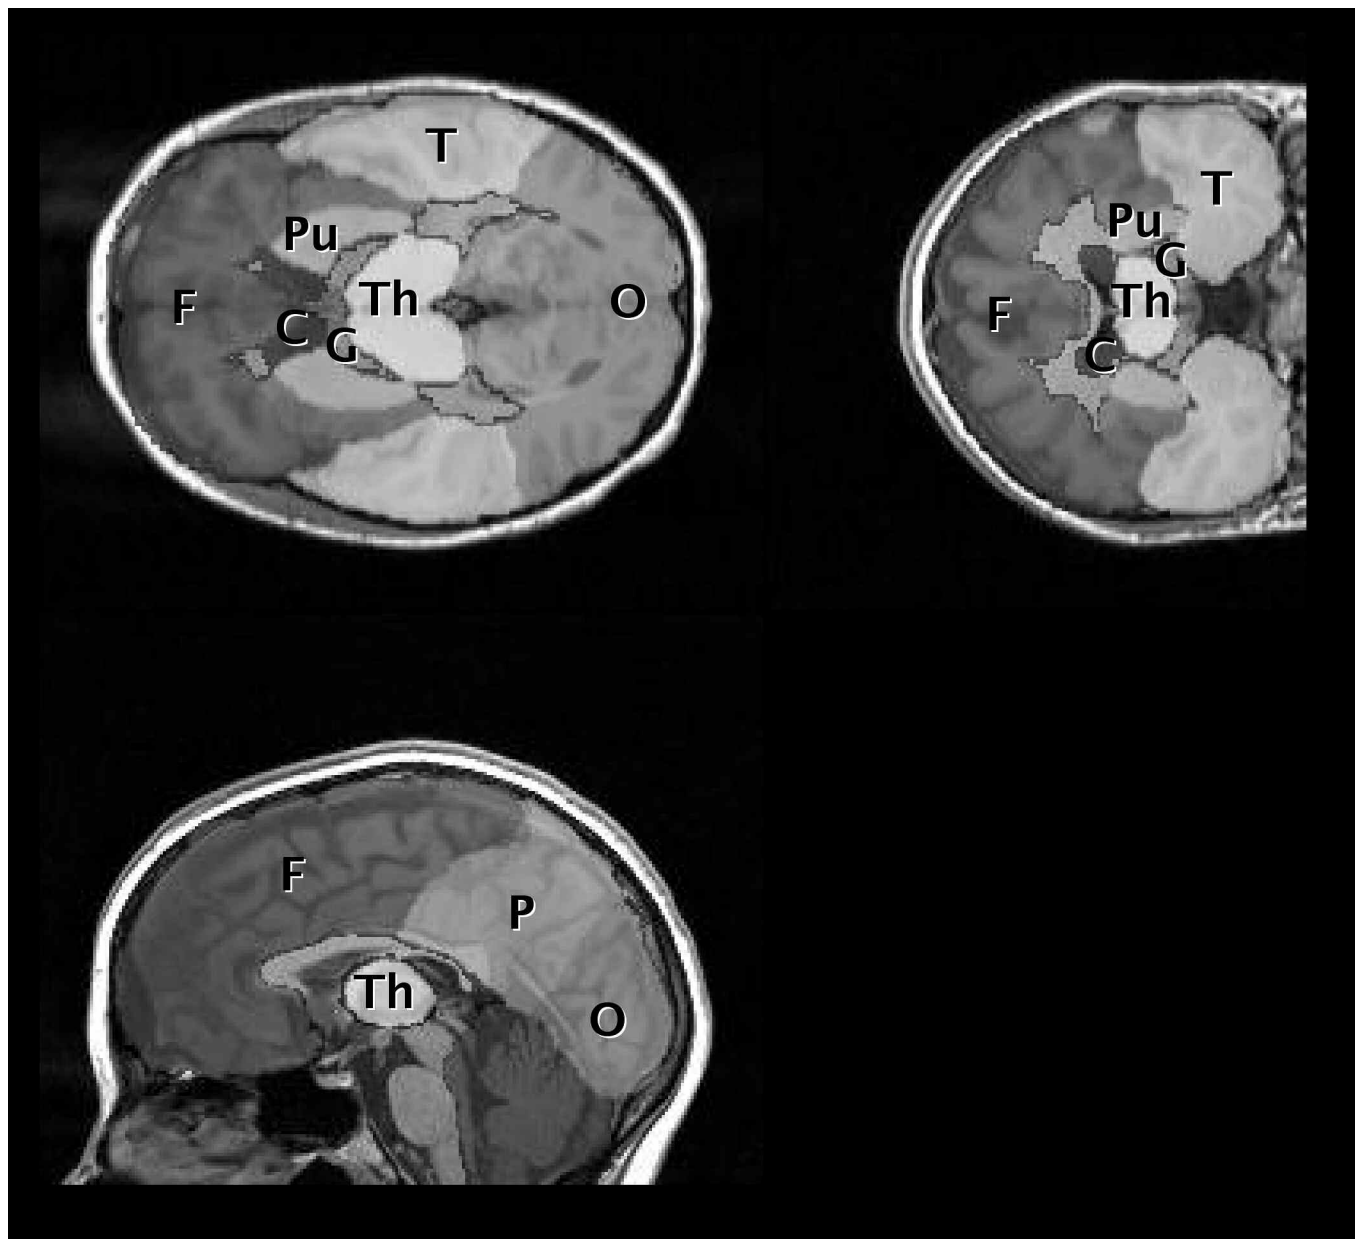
T1-weighted image from one control patient with regions of interest overlaid. F: frontal, P: parietal, T: temporal, O: occipital, G: globus pallidus, C: caudate, Pu: putamen, Th: thalamus.
